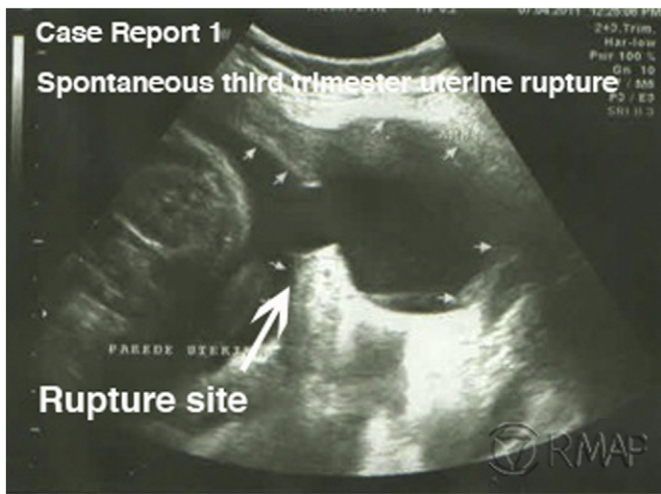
Transabdominal ultrasonography demonstrating uterine rupture associated with prolapse of the amniotic membranes across the uterine wall near the posterior left uterine horn (arrow).
